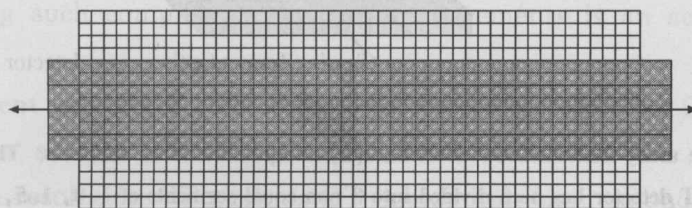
MSCT Fixed array MSCT detector. (a) Single column of elements. The 20 mm length of the single section CT detector has been divided into 16 equal segments of 1.25 mm each. (b) The columns of the fixed array detector are packed together to form a curved 2D detector array
